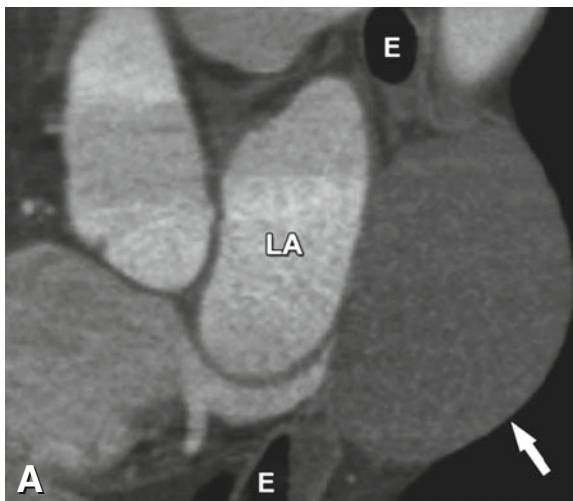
Mediastinal cystic lesion on cardiac CT in a 72-year-old man who presented with dyspnea and atypical angina pectoris (*arrow* in Panel A, sagittal reformation). An oval hypoattenuating 8-cm mediastinal tumor was found posterior to the left atrium (*LA*). The differential diagnosis in this situation included a pericardial, bronchogenic, or lymphatic cyst, or less likely, a lymphoma or a malignant tumor arising from a different origin (e.g., the esophagus, E). Magnetic resonance imaging was performed for further clarification (Panel B) and demonstrated a fluid level (*arrow*). Thus, the lesion was assumed to most likely represent a benign cyst, e.g., of lymphatic origin (lipid-water level) or originating from the pericardium. This case highlights the importance of the availability of different modalities for clarification of noncardiac findings in cardiac CT
